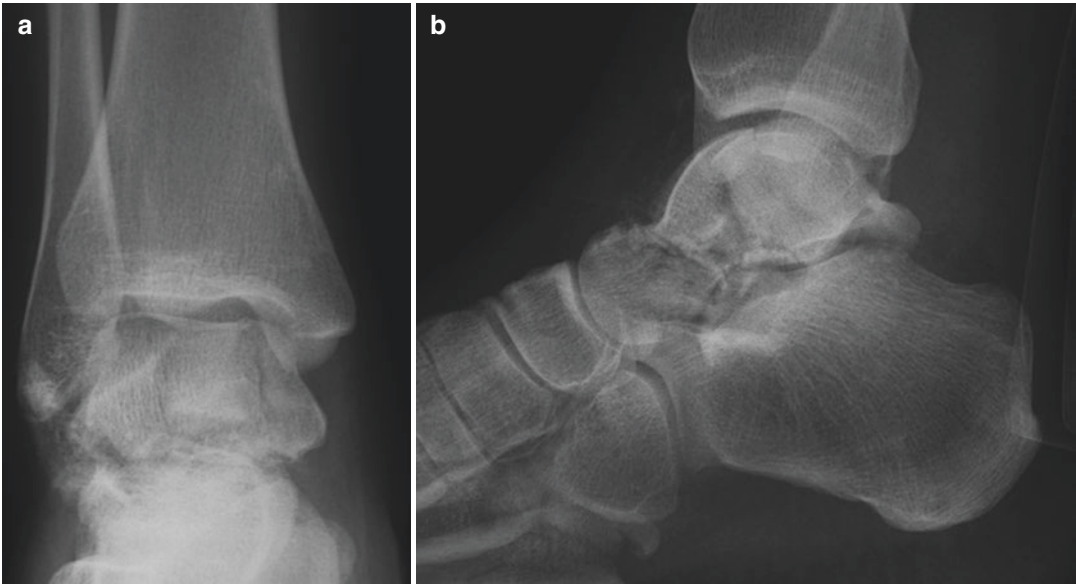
Injury ankle radiographs depict a comminuted talar body and associated talar neck fracture (type C3), seen in the anteroposterior and lateral views
